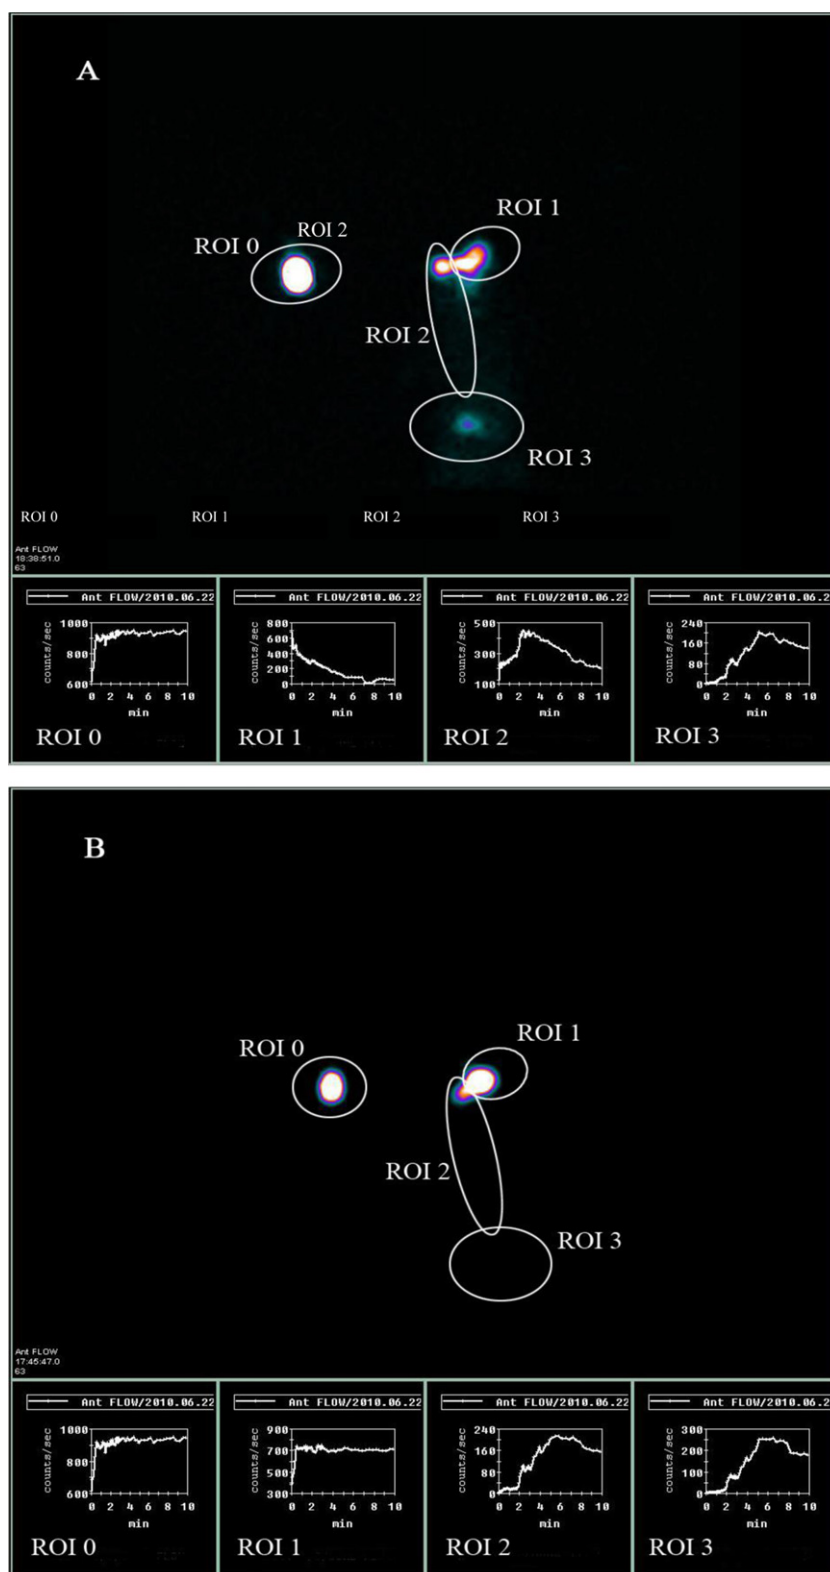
The curves of the remaining activity vs. the time (A): in vivo elimination of the control solution and (B): formulation F1-3. Typical scintigraphic images divided into four regions of interest (ROIs): (0) the position reference, (1) the pre-corneal surface, (2) the lacrimal duct, and (3) the oropharynx.
